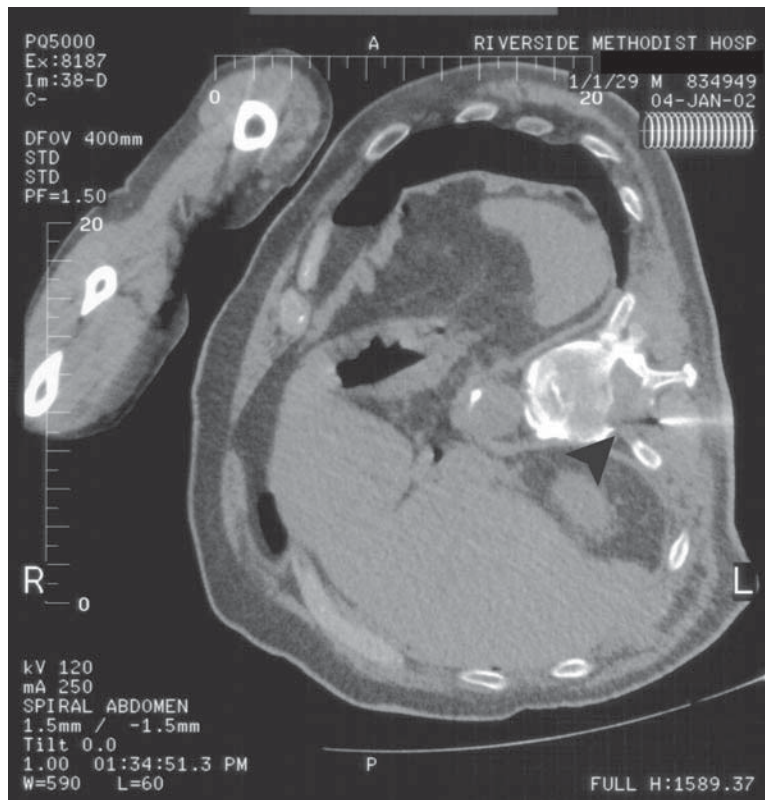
Metastatic lesion involving the vertebral pedicle with extension into the surrounding soft tissues. CT allows visualization of both bone and soft tissues and safe and accurate needle placement.
